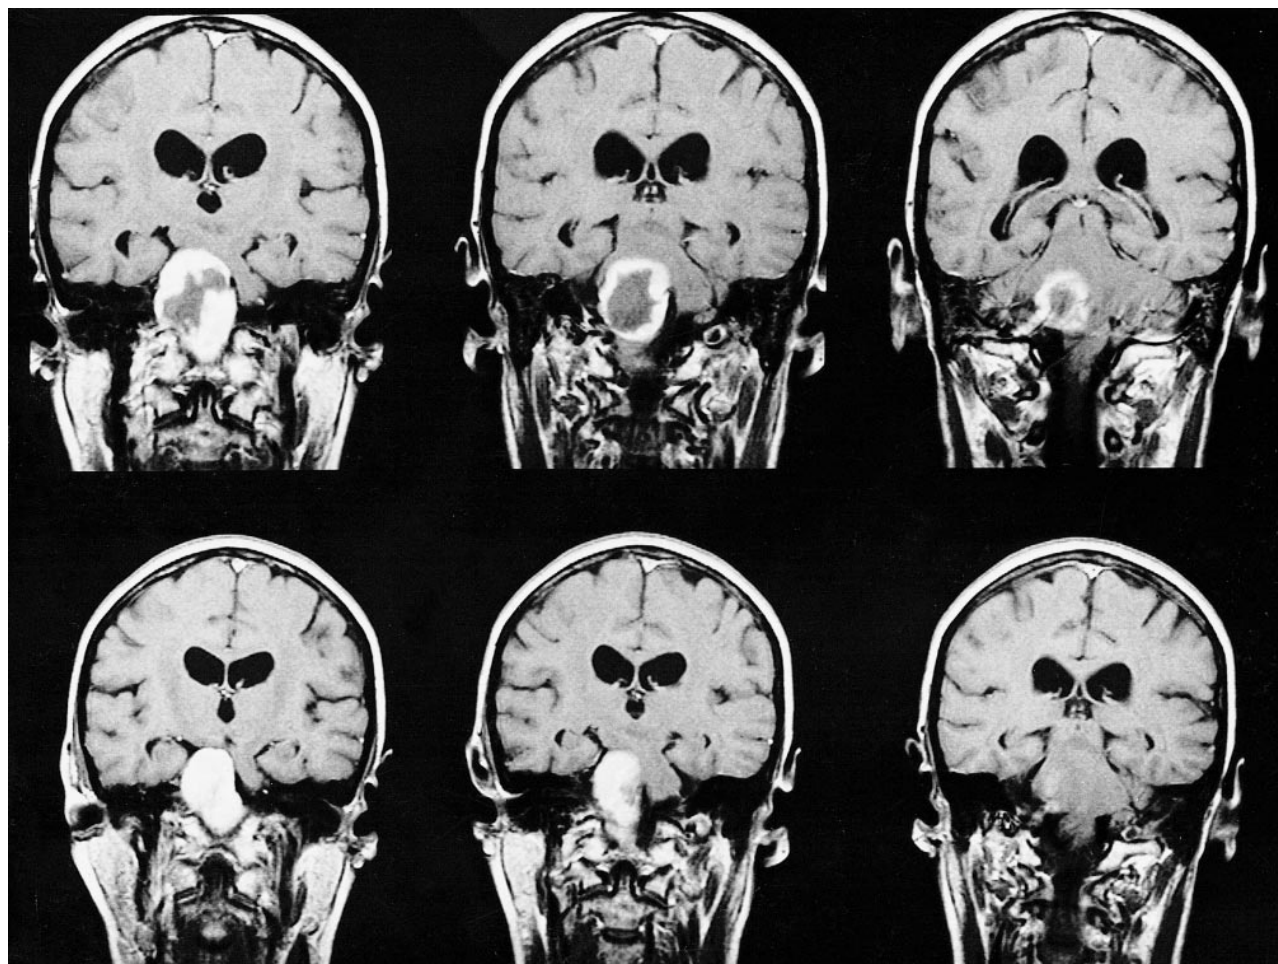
Coronal T1-weighted MR images of the same patient as in Figure 2 after administration of contrast material show reduction in tumor size.
